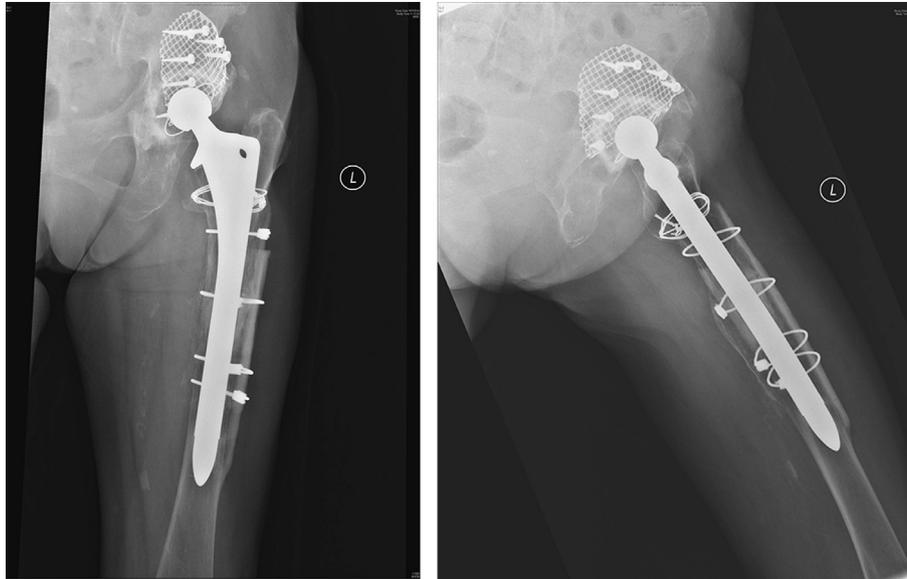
Latest radiograph at 5 years 8 months showing persistence of the horizontal radiolucent line at the distal tip of the femoral stem.
